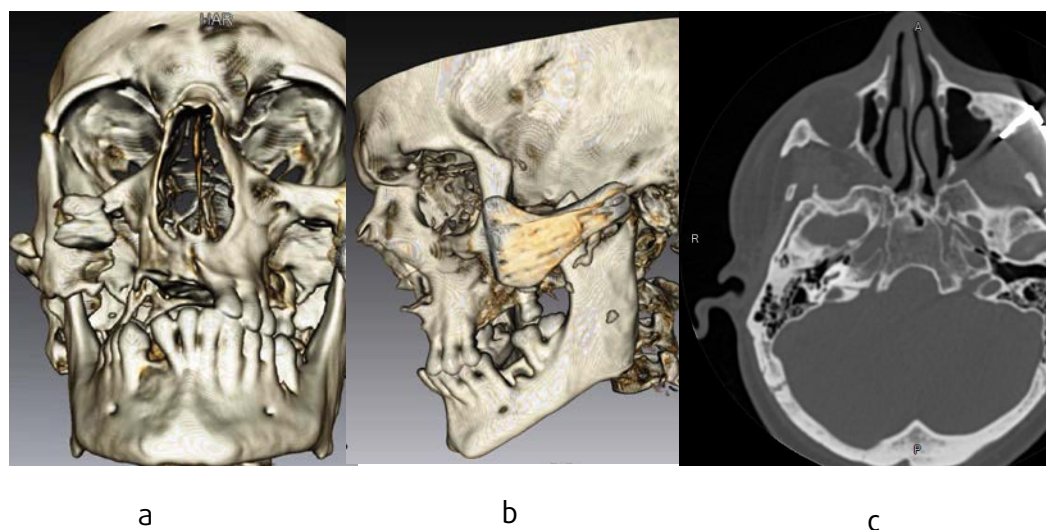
Roentgenological picture of patient's K. facial skull after surgery: a – frontal projection; b – left lateral projection; c – axial projection
